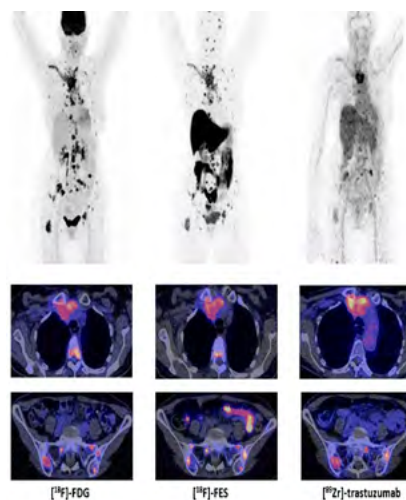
Comparison of 18F-FDG, 18F-FES and 89Zr-trastuzumab in the same patient [26, listed but not discussed, published in accordance with the Open Access Licence]
